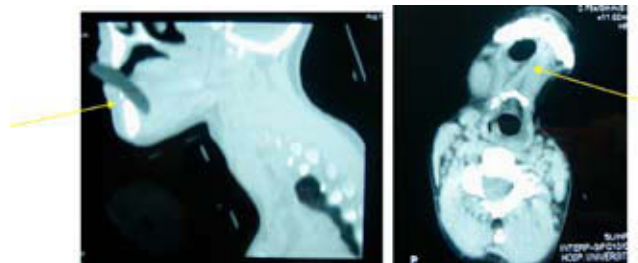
X-ray study. CT scan: sagittal and axial sections. Note the foreign body in the floor of the mouth. The axial plane shows the dissection of muscle planes with no radiological signs of haematoma or affection of the right submandibular gland.
